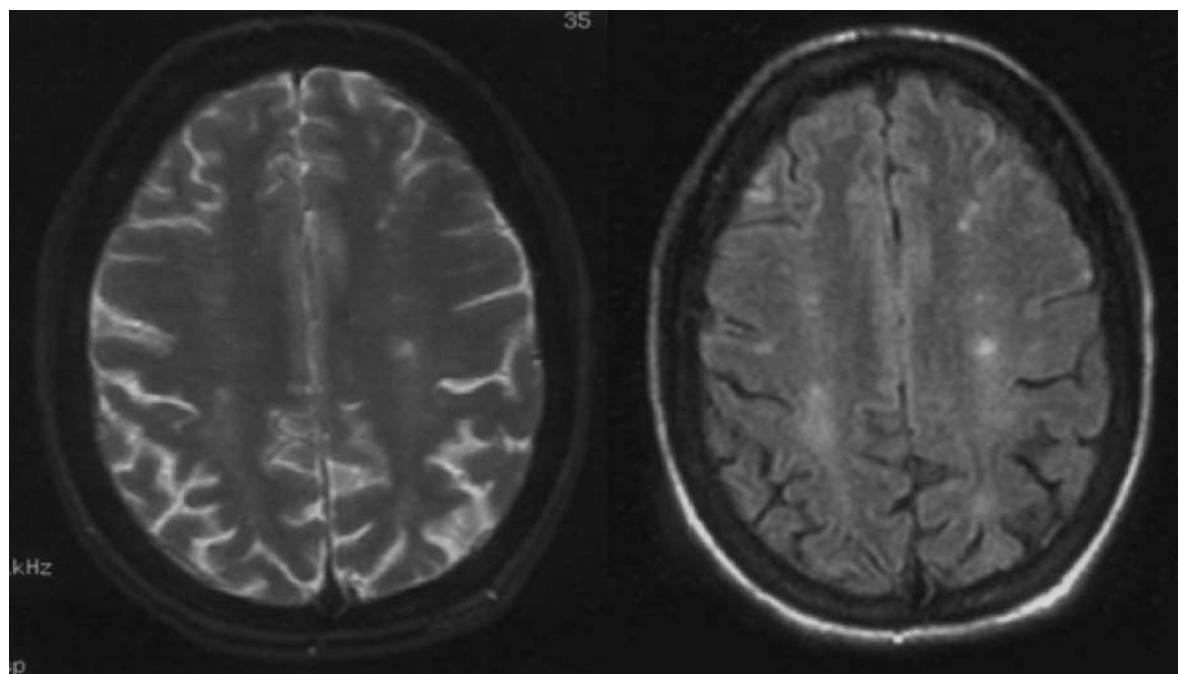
FLAIR and T2 in Neuropsychiatric SLE. The figure on the left is an axial slice demonstrating CSF and cortical, subcortical, and deep white matter lesions by conventional T2 (TE = 100 ms; TR = 3000 ms). The figure on the right demonstrates the same slice by FLAIR (TR = 10,000 ms, TE = 145 ms, TI = 2200 ms). As can be seen by comparison, the signal from CSF is markedly attenuated (darker) with FLAIR, and the lesions (areas of increased signal) have greater conspicuity on FLAIR relative to the corresponding T2 image. The focal and diffuse, ill-defined lesions are best seen on FLAIR compared to T2. Although the larger focal white matter lesion is seen well in the T2 image, the conspicuity is far better on the FLAIR image. Similarly, the ill-defined white matter lesions are barely seen on the T2 weighted image, are much more obvious on the FLAIR image. Finally, the cortical/subcortical lesion (which is a reversible lesion typical of lupus acute leukoencephalopathy) in the frontal lobe is not apparent at all by T2 (left), but is obvious by FLAIR (right).
